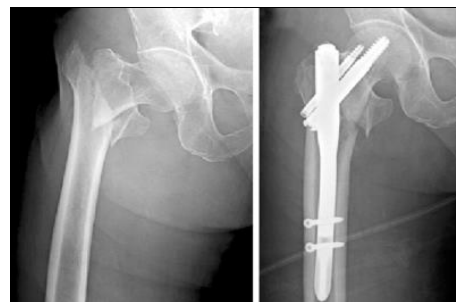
Pre op and Post op X-rays (PFN)
